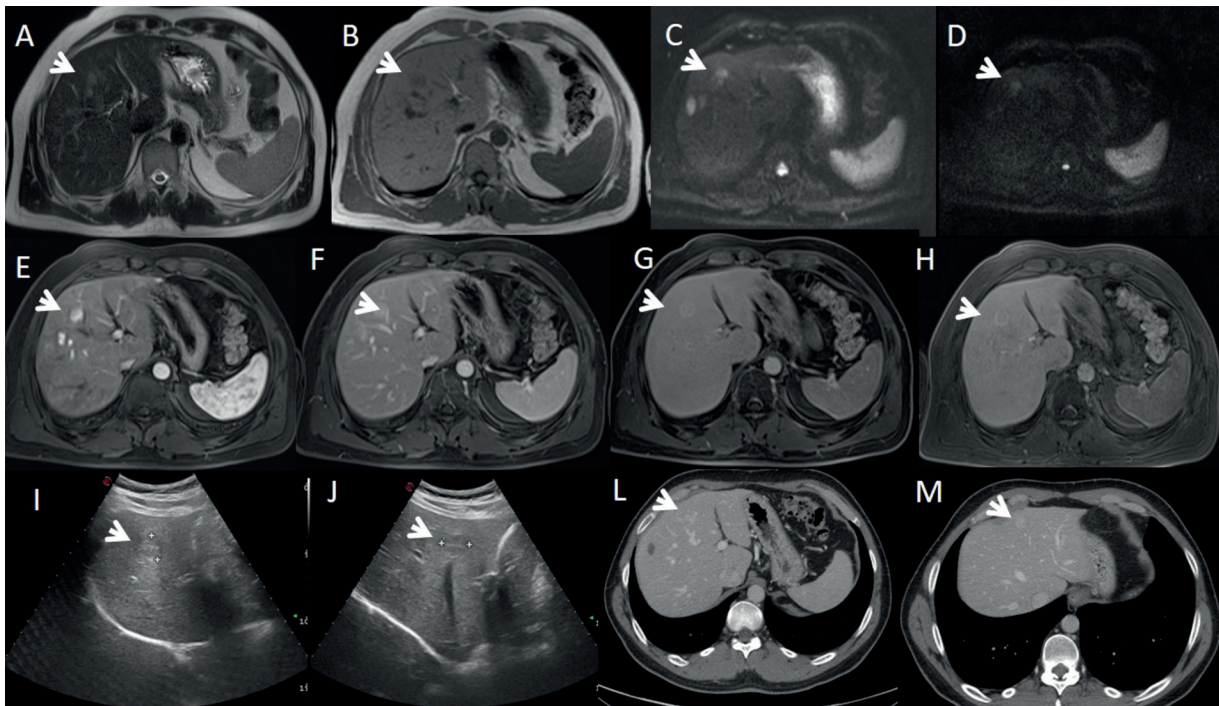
42-year-old male with history of rectal cancer. Oxaliplatin-induced lesions. Liver lesions appear hyperintense (arrow) on T2 W sequence (A) hypointense (arrow) on T1-W in-of-phase sequence (B), with restricted diffusion (arrow) on b 50 s/mm² (C) and b800 s/mm² (D). During contrast study the lesions show hyperintense signal (arrow) on arterial phase (E) and portal phase (F), isointense signal with hyperintense peripheral rim (arrow) on transitional (G) and EOB phase (H). US (I and J) show solid, isoechoic to hypoechoic lesions (arrow). In (L-M) CT scan on portal phase of dynamic study: the lesion is hyperdense or isodense with hyperdense peripheral rim (arrow).
